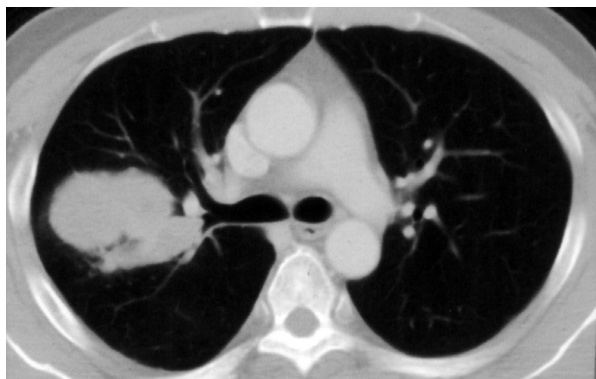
Computed tomography. Under lung window of computed tomography, a lobulated tumor noted in the right upper lobe, measuring about 7 x 4.5 cm in size.
